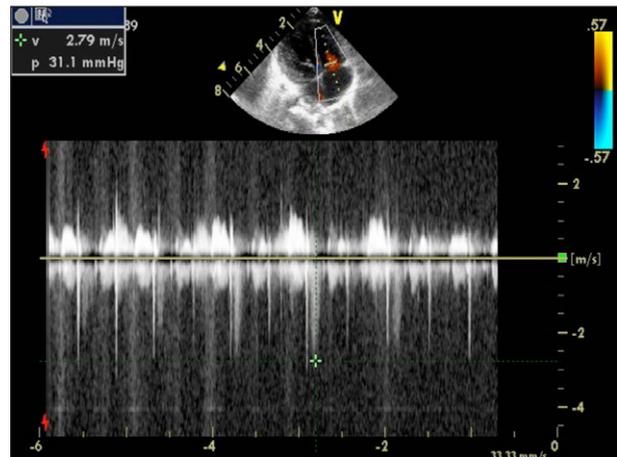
Echocardiography findings at 7 months of age (after 14 days of sildenafil administration). Maximal gradient right ventricle/right atrium was 31 mmHg. Systolic right ventricular pressure was 38 mmHg.
